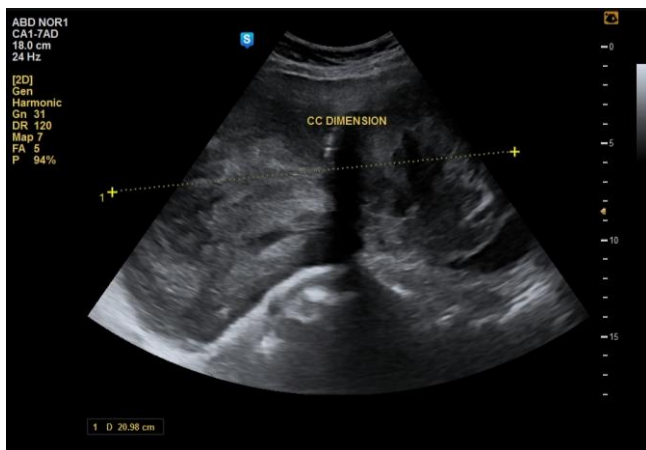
Grey scale ultrasound image demonstrates a large pelviabdominal lesion, heterogenous in echotexture and free fluid in POD
